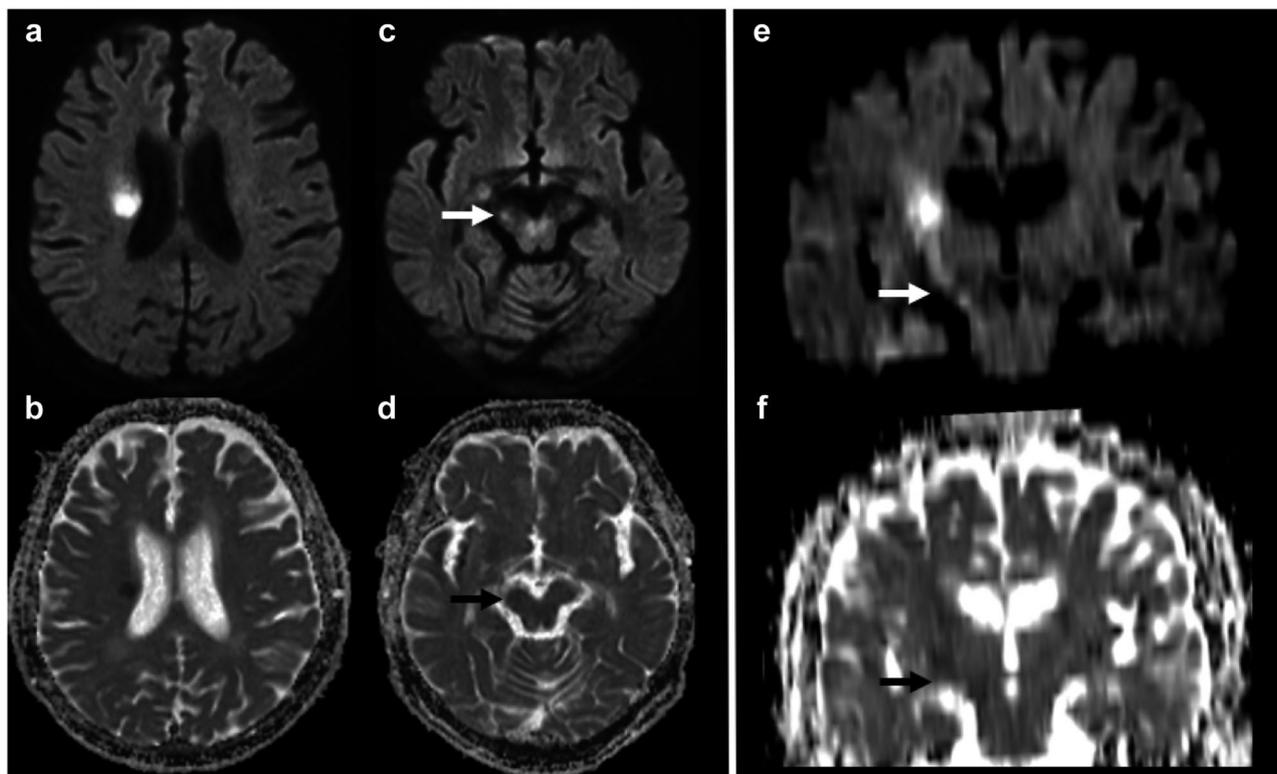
Findings of a representative case. Cerebral infarction is observed in the right lenticulostriate artery (LSA) area of a 72-year-old woman. Diffusion-weighted MRI scanning was performed 11 days after ischemic stroke infarction experienced by the patient. Axial diffusion-weighted imaging (DWI) reveals an acute infarction, classified as a small-artery disease in the right paraventricular corona radiata (a), with a decreased axial apparent diffusion coefficient (ADC) map (b). Imaging of the cerebral peduncle and internal capsule demonstrates hyperintensity on the axial and coronal DWI (c and e), as well as hypo-intensity on the axial and coronal ADC map (d and f), in the descending cortical tract. Multiplanar reconstruction generated coronal DWI and ADC map section images (e and f). MRI: magnetic resonance imaging
